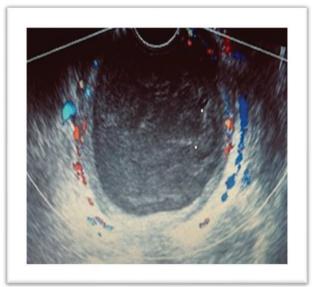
Doppler ultrasound of 24 years old patient of endometriosis with continuous bleeding and deranged lipid profile.
